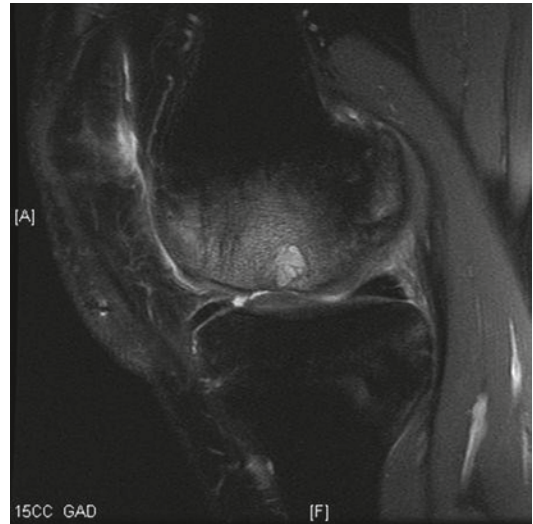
Magnetic resonance imaging (MRI) (*sagittal cut*; proton density, fat suppressed sequence with intravenous Gadolinium contrast) of the medial femoral condyle after failed microfracture showing a large subchondral cyst with extensive subchondral edema
